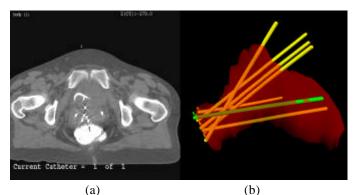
(a) CT presentation and (b) 3D view of 8 plastic catheters in the case of cervix tumor.
